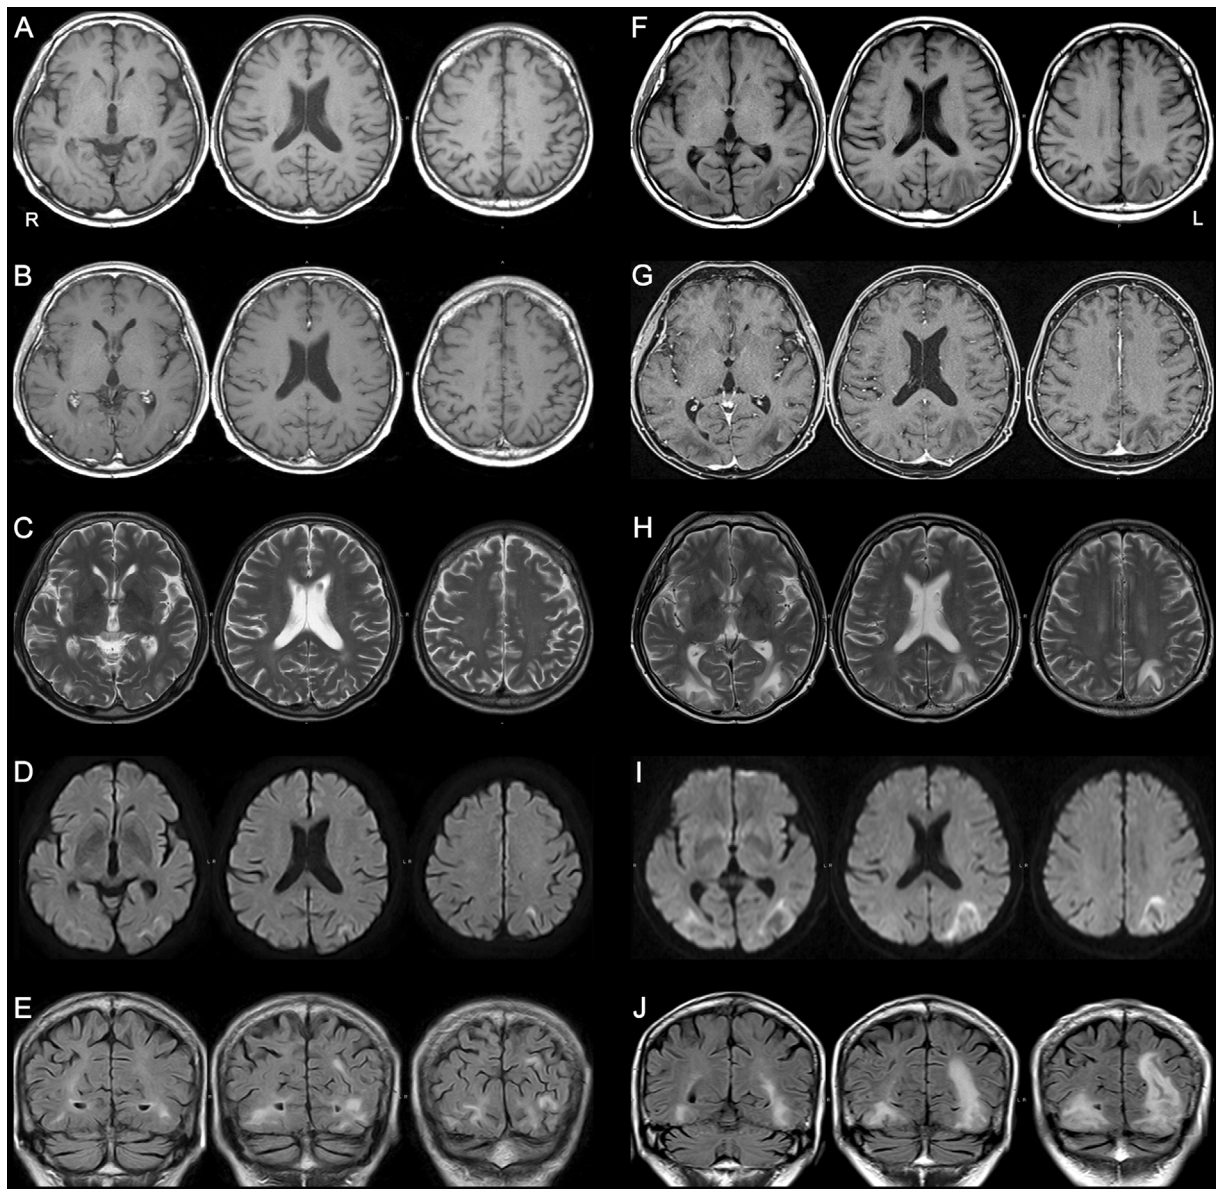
Magnetic resonance imaging (MRI) at two time points in the clinical course. T1-weighted (A, F), gadolinium-enhanced T1-weighted (B, G), T2-weighted (C, H), diffusion-weighted (D, I), and fluid-attenuated inversion recovery (E, J) images are displayed. A set of MRI scans was performed after a one-month history of progressive visual disturbance (A-E), showing white matter lesions in the occipital lobe without gadolinium enhancement. Two months later, another set of MRI scans was performed (F-J), showing enlarged white matter lesions that included gray matter with cortical laminar necrosis and negative gadolinium enhancement.
